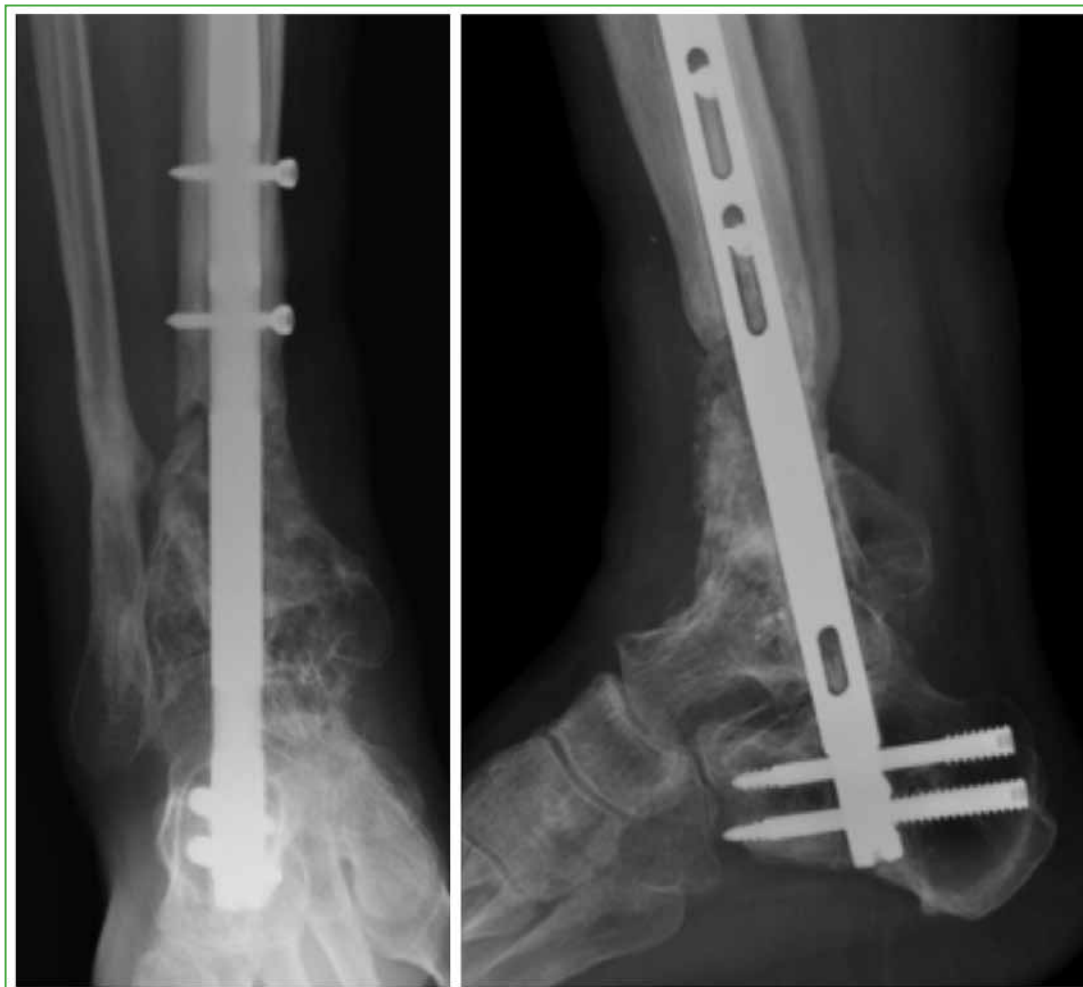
Anteroposterior and lateral ankle radiographs, 11 months after the second surgical stage.
